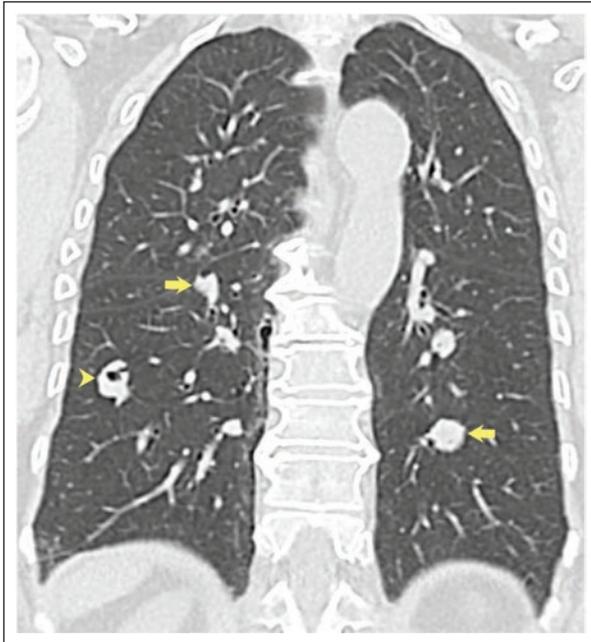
Nodular amyloidosis. A chest CT coronal reconstruction shows solid pulmonary nodules in the lower lobes (arrows) with nodule cavitation in the right lower lobe (arrowhead).
